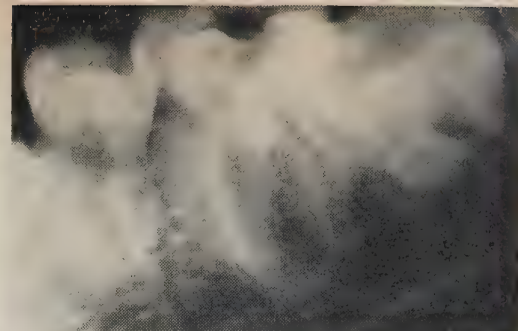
The lingual root is brought into view when the central radiographic beam is shifted five degrees laterally.
